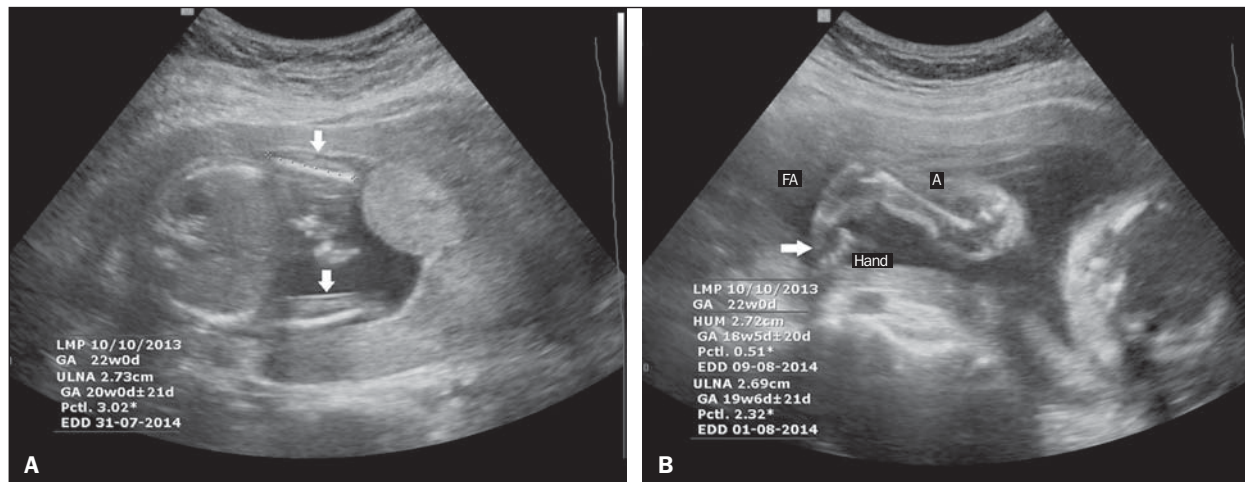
Ultrasound images of a fetus with TAR syndrome, at 21 weeks of gestation. A: Axial plane scan at the abdominal circumference measurement level, showing shortening of the ulnae and the absence of radii (white arrows). B: Sagittal plane scan at the level of the humeral length measurement, showing internally rotated hands (white arrow). FA, forearm; A, arm.
